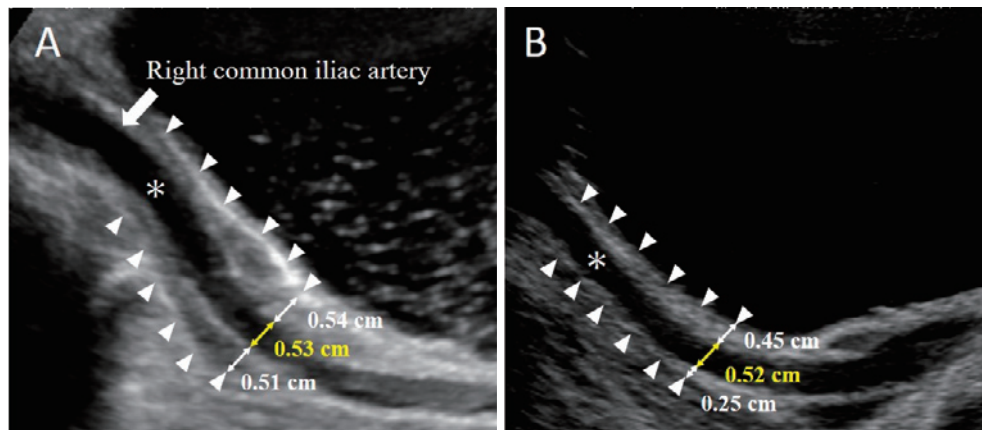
Serial ultrasound images of the right common iliac artery in the presented case before (A) and after (B) treatment with corticosteroids. The outer layer of the common iliac artery remarkably improved after treatment, while the arterial lumen diameter remained unchanged (arrow head: the outer layer of the common iliac artery, asterisks: the arterial lumen).
